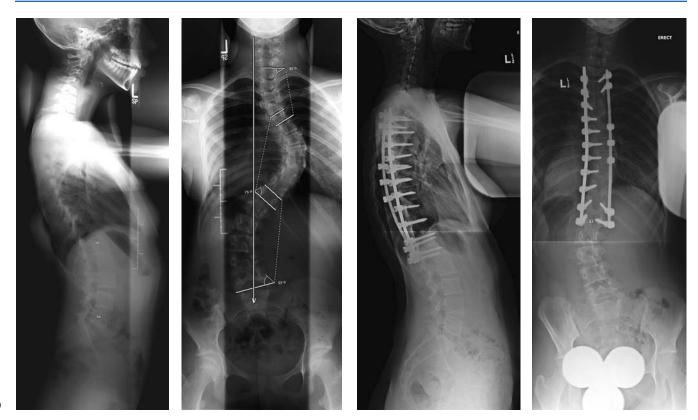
Trunk decompensation following selective thoracic fusion with modern implant systems. (A,B) Preoperative radiographs demonstrating a 75-degree thoracic curve and a 57-degree lumbar curve. (C,D) Two-year postoperative radiographs demonstrating
